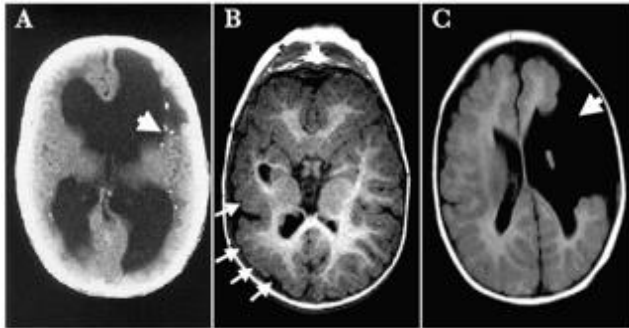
Imaging findings in congenitally human CMV-infected neonates. Computed tomography (A) and magnetic resonance (B and C) CNS imaging of three infants with severe symptomatic congenital hCMV infection with CNS involvement. The classical pattern of injury is characterized by periventricular calcifications (A, arrow), abnormalities of neuronal migration, such as polymicrogyria (B, arrows) and, in extremely severe cases, profound structural defects such as porencephalic cysts with associated schizencephaly (C, arrow). Adapted from (de Vries et al., 2004).*
